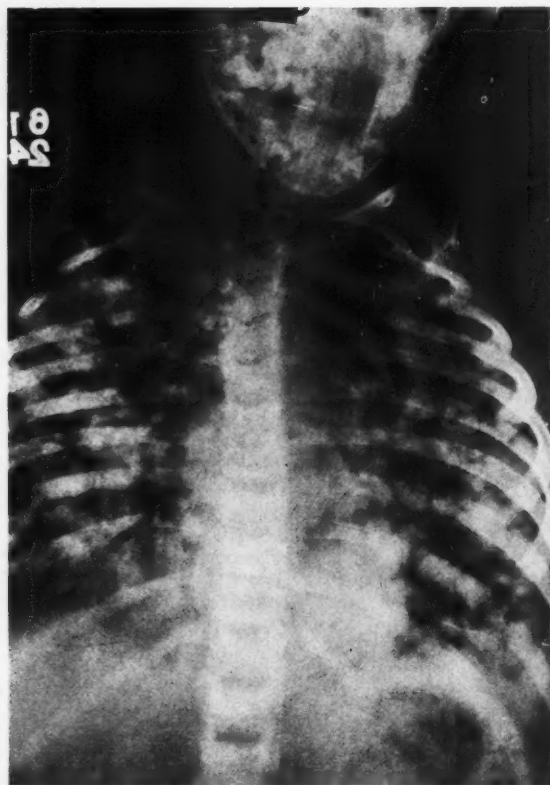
Case 4. Roentgenogram of chest taken June 10, 1931, showing metastases in lungs.
